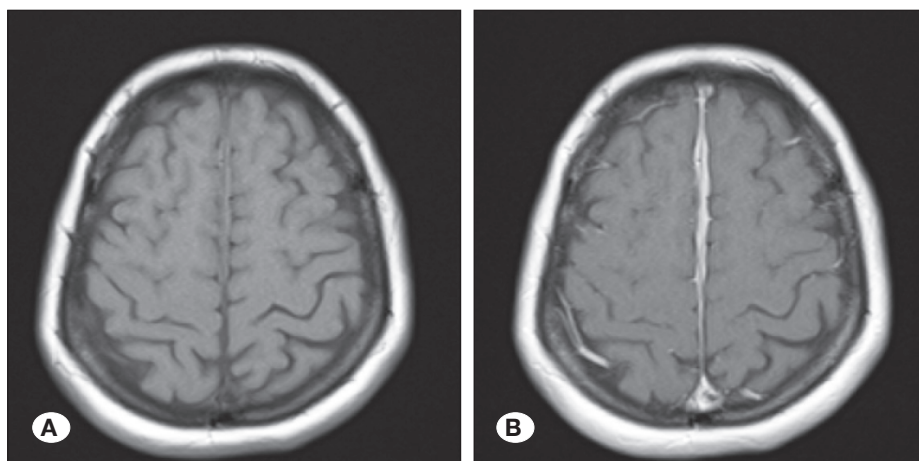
Post-operative third-month axial gadolinium-enhanced (A), and non-enhanced (B) T1W MR images show that the tumour spontaneously regressed.
